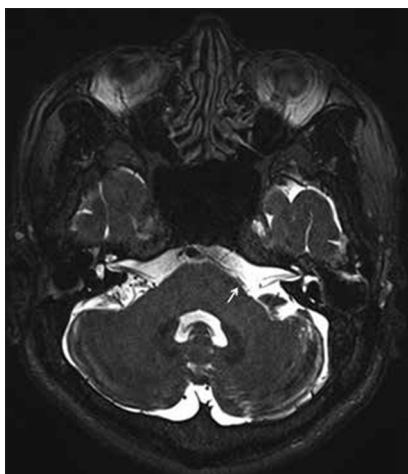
Preoperative T2 magnetic resonance imaging of the patient. A small vessel having a contact with root exit zone of CN VII is observed in the left side (white arrow)
